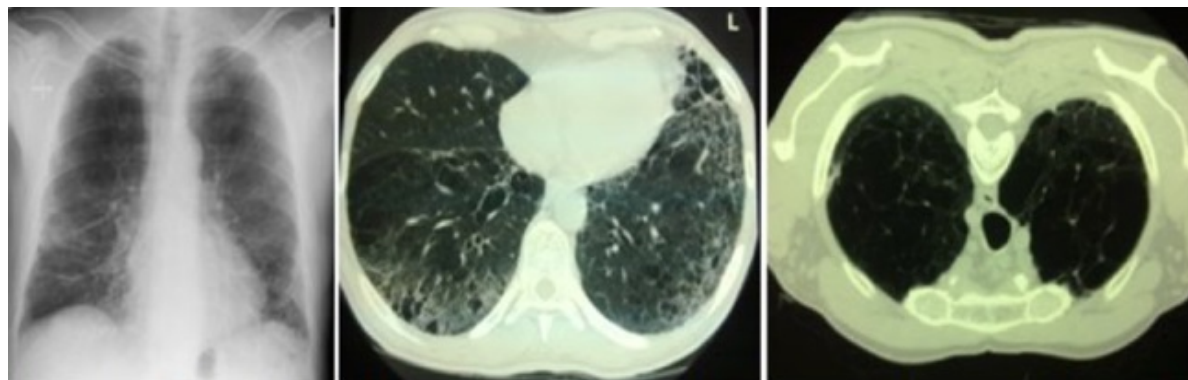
Chest X-ray. HCRT tórax base. HCRT tórax vertice.
